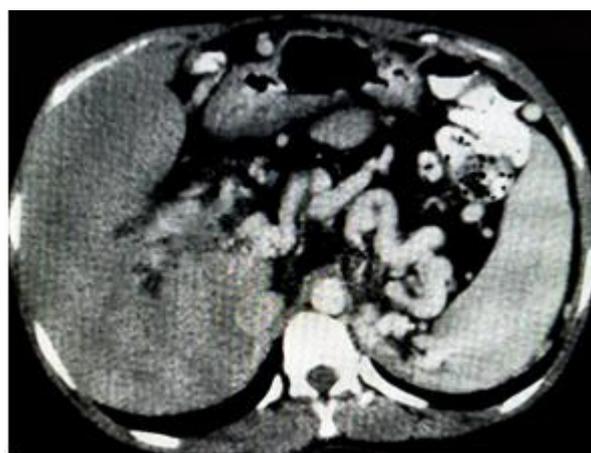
CT portalphase showing dilated splenic vein with dilations suggestive of varices
